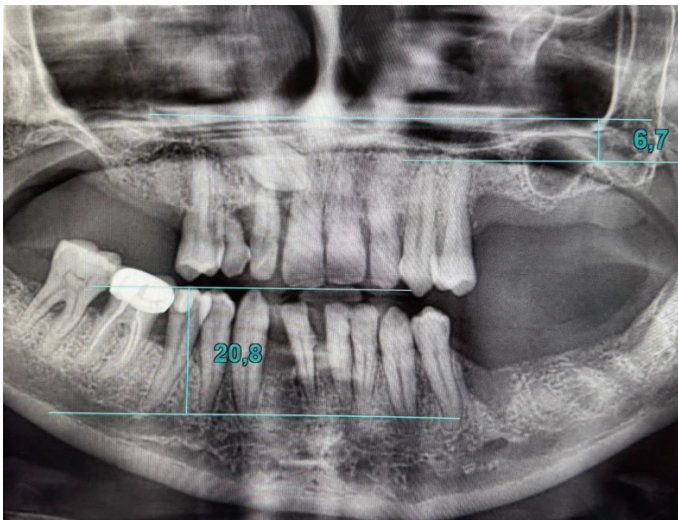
The extent of pneumatization was calculated using post-extraction radiographs.
